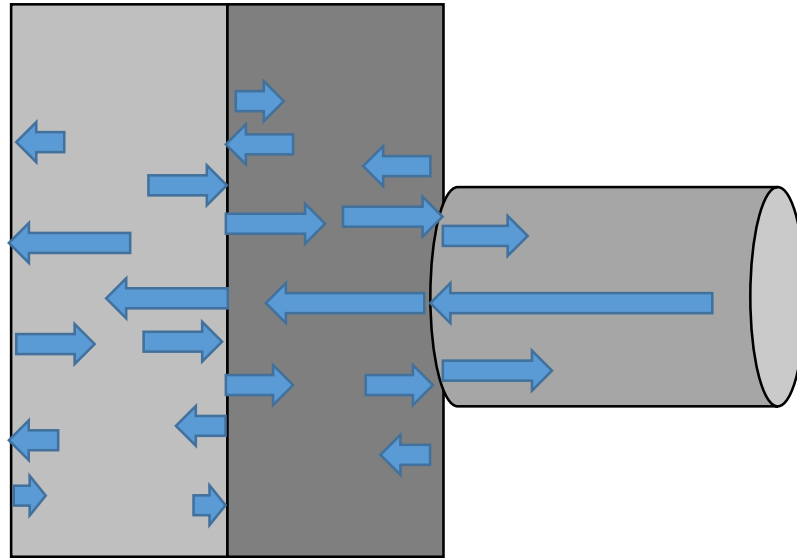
Ultrasound wave behavior in a multilayer medium
